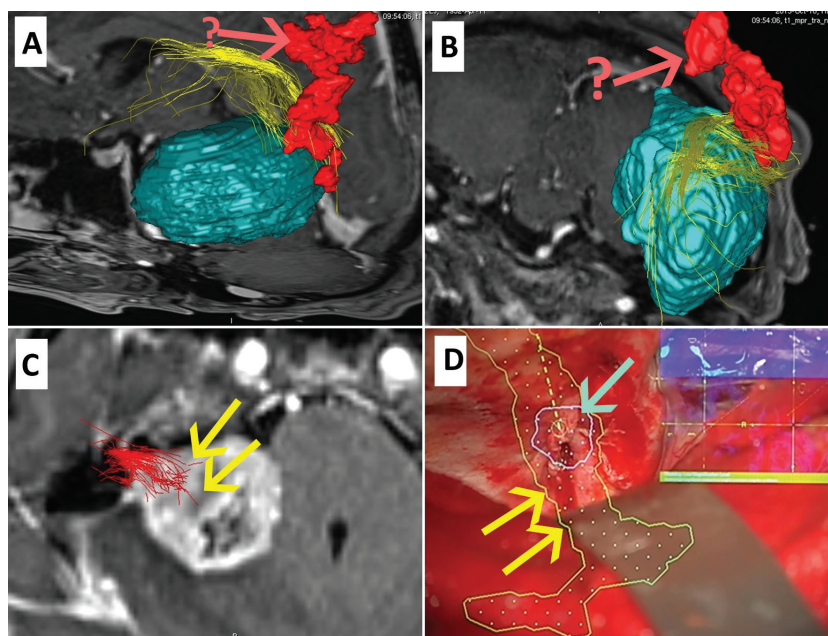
Diffusion tractography (diffusion tensor imaging — DTI) does not represent real white matter pathways. Sagittal (A) and coronal (B) planes of a left temporal lobe tumour (blue model). Wernicke area (red model) is estimated by means of functional magnetic resonance imaging (MRI). Arcuate fasciculus (pictured with yellow) terminate only at a part of the Wernicke area (red arrow with a question mark), suggesting the possible inaccuracy in DTI and/or functional MRI method. Several methodological limitations of DTI method refer also to visualising cranial nerves, including (C) facial nerve (yellow arrows) bending over a cerebello-pontine angle neuroma and (D) optic nerve (yellow arrows) distorted by a small schwannoma (blue arrow).
